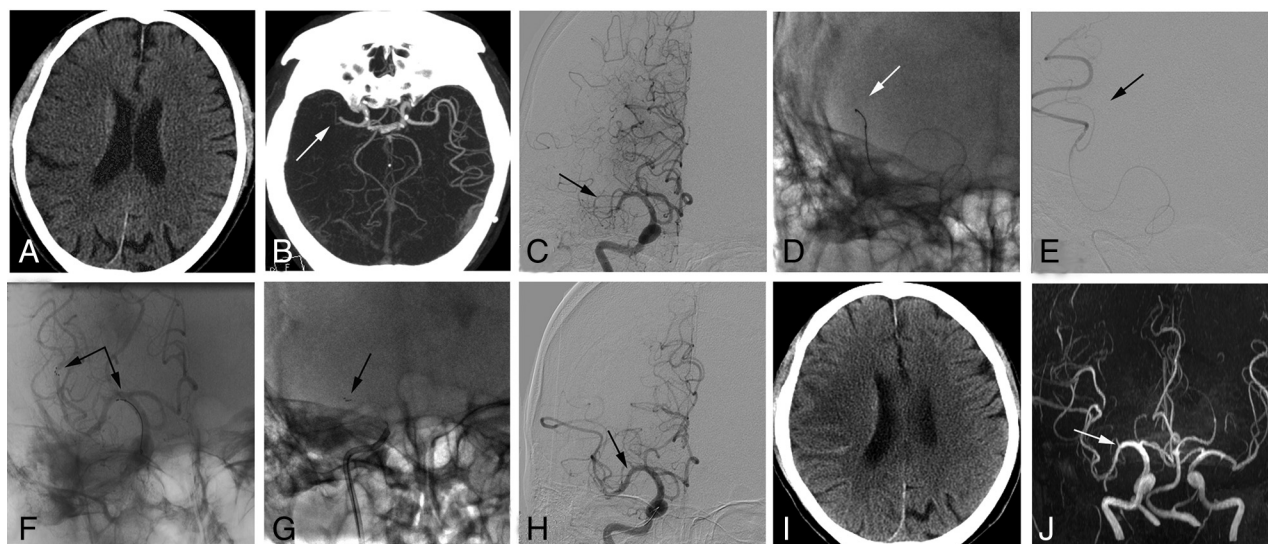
A 72-year-old male patient who presented with weakness of the left limb for 4 hours. *A*, CT on admission does not show a large-territory infarct. *B*, CTA shows right MCA segment occlusion (arrow). *C*, DSA confirms occlusion of the right MCA segment (arrow). *D*, A microguidewire crosses the occluded artery. *E*, A microcatheter crosses the thrombus to the distal segment through the microguidewire. *F*, Angiogram after deployment of the Solitaire 6 × 30 mm stent retriever shows restoration immediately in the MCA. Arrows show proximal and distal markers of the Solitaire device. *G*, The stent retriever is unsheathed with the microcatheter being pulled back simultaneously (arrow). *H*, After 3 passes of thrombectomy, the final angiography shows a mTICI flow of grade 2B in the right MCA with favorable perfusion (arrow). *I*, CT postprocedure at 24 hours shows no obvious intracerebral hemorrhage. *J*, MRA postprocedure at 7 days shows good recanalization (arrow).
